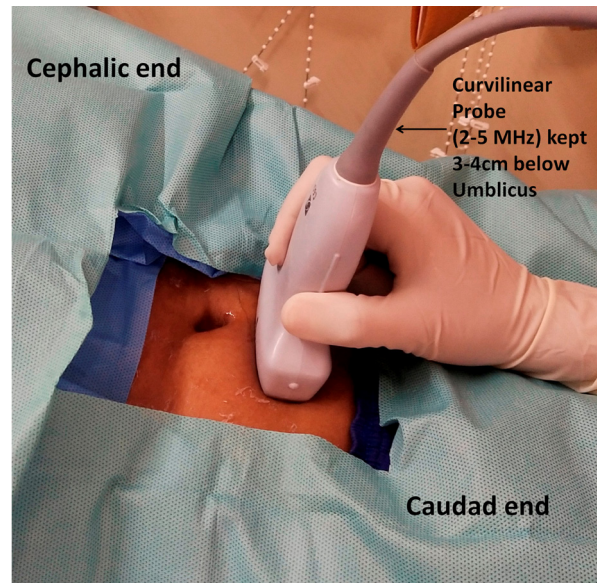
Curvilinear ultrasound probe (2-5MHz) kept in the transverse plane 3-4 cm below the umbilicus.
